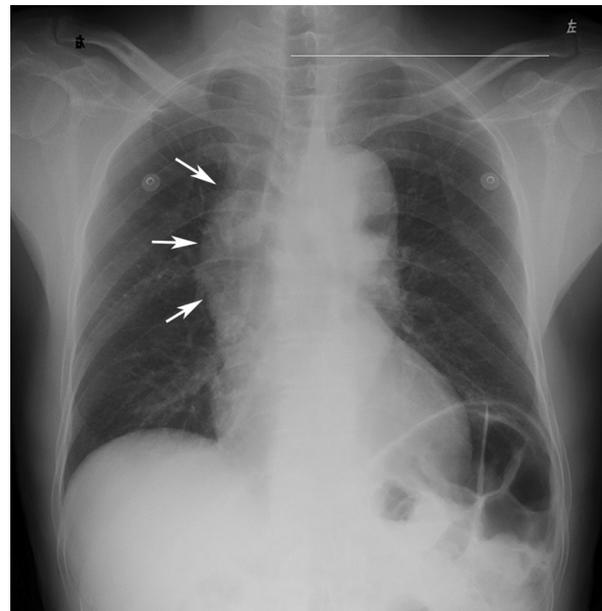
x-ray of the chest (AP view) reveals mediastinal widening (arrow).
